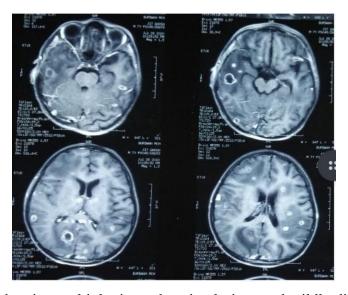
MRI Brain showing multiple ring enhancing lesions and mildly dilated supratentorial ventricles
